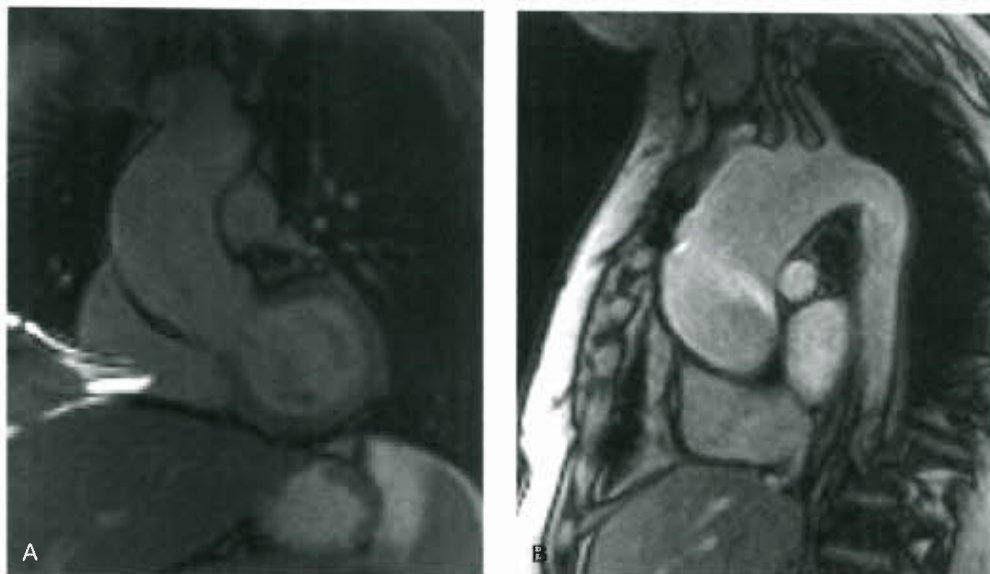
Cardiovascular magnetic resonance imaging (CMR). A: 26-year-old with BAV with no aortic stenosis/aortic valve insufficiency, CMR demonstrates aortic root enlargement measuring 4.7 cm at the widest diameter mid ascending aorta. B: A 32-year-old with BAV, mild AS, and large ascending aortic aneurysm measuring 5.2 cm with the widest diameter just proximal to the take off of the right innominate artery. Echocardiographic maximal diameter just above sinuses of valsalva was 4.0 cm, therefore underestimating the maximal diameter of the ascending aorta.
